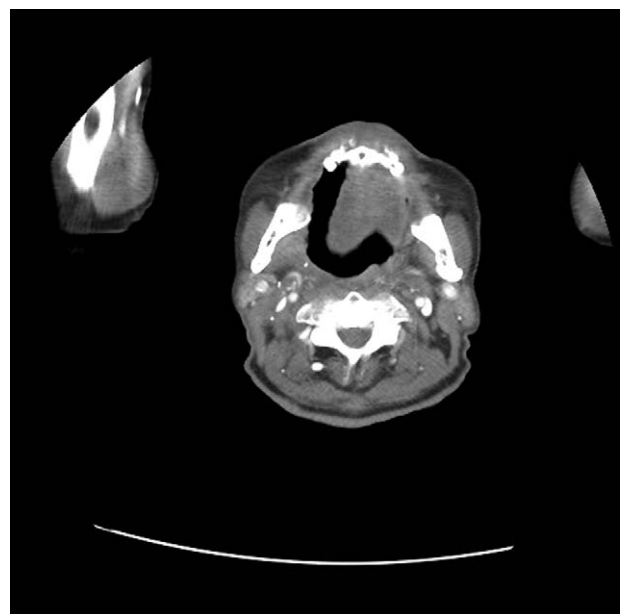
Computed tomography (CT) scan shows evidence of right oropharyngeal mass excision and right neck dissection without recurrent lesion.
